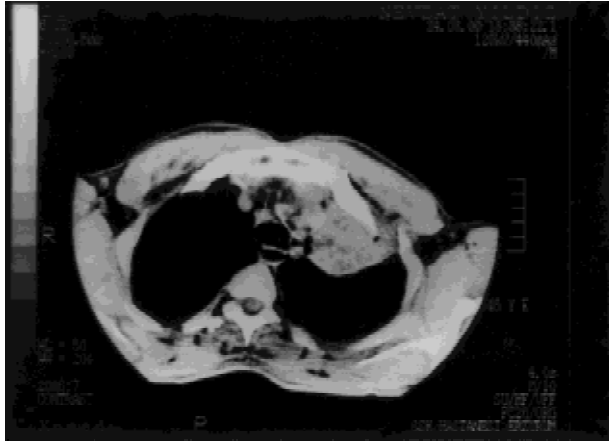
Computed tomography shows multiple cystic spaces in the left upper lobe, in which the volume was diminished.
